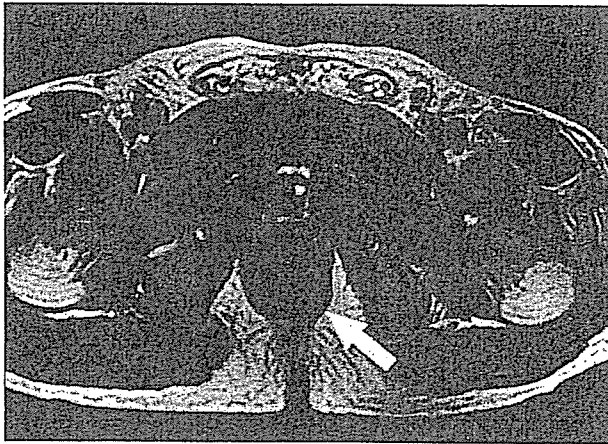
Axial T2-weighted image demonstrated the increased signal intensity at the external anal sphincter muscle that was adjacent to the tumor. (arrow)
